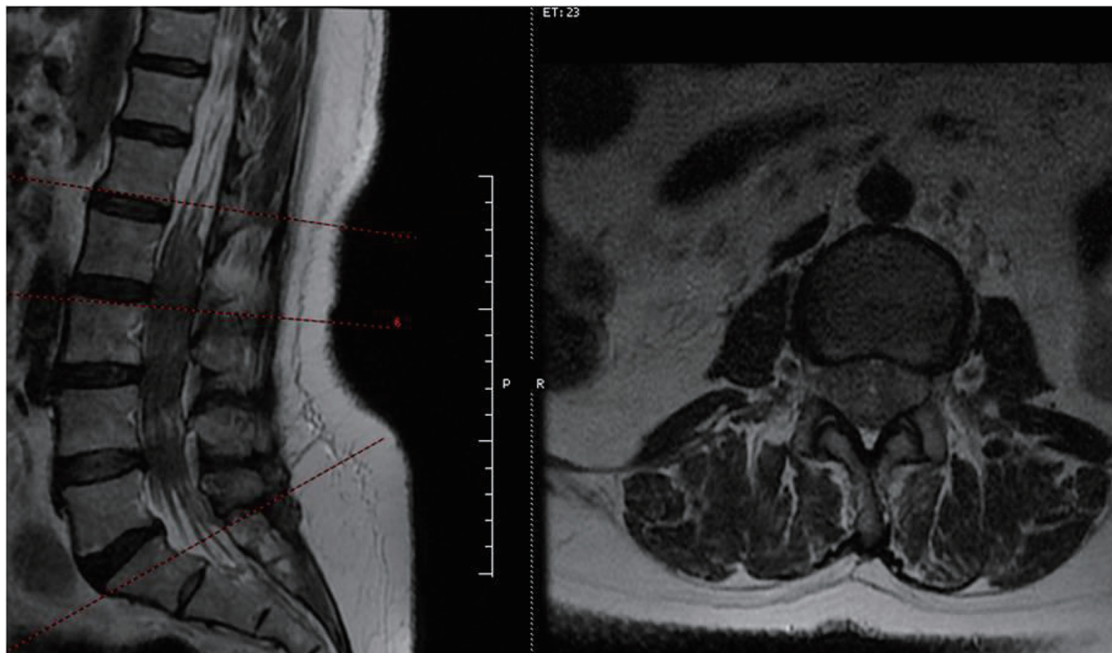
Follow-up lumbar MRI at 6 months demonstrating relatively relaxation of nerve rootlets with persistent edema. MRI: magnetic resonance imaging.
